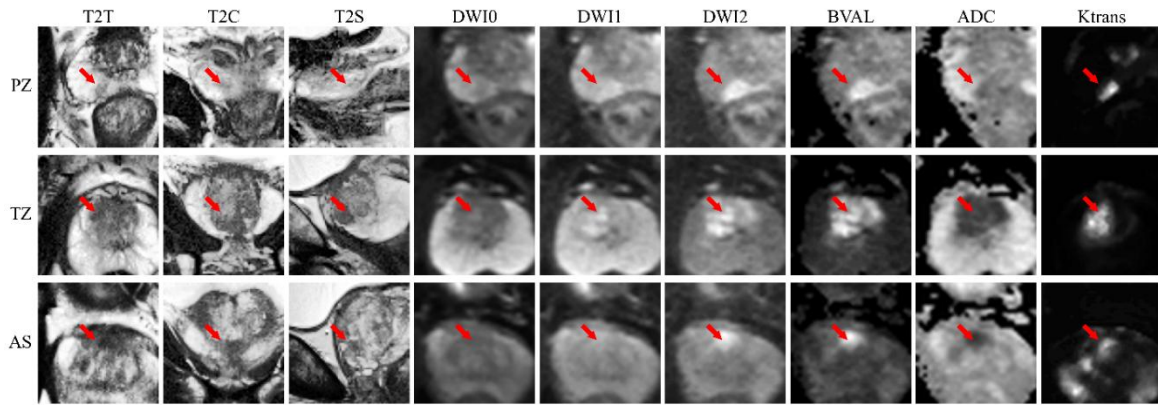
Multi-zone PCa Visualization: Preprocessed MRI Slices Showing Lesion Appearance in PZ, TZ, and AS Regions of the Prostate
